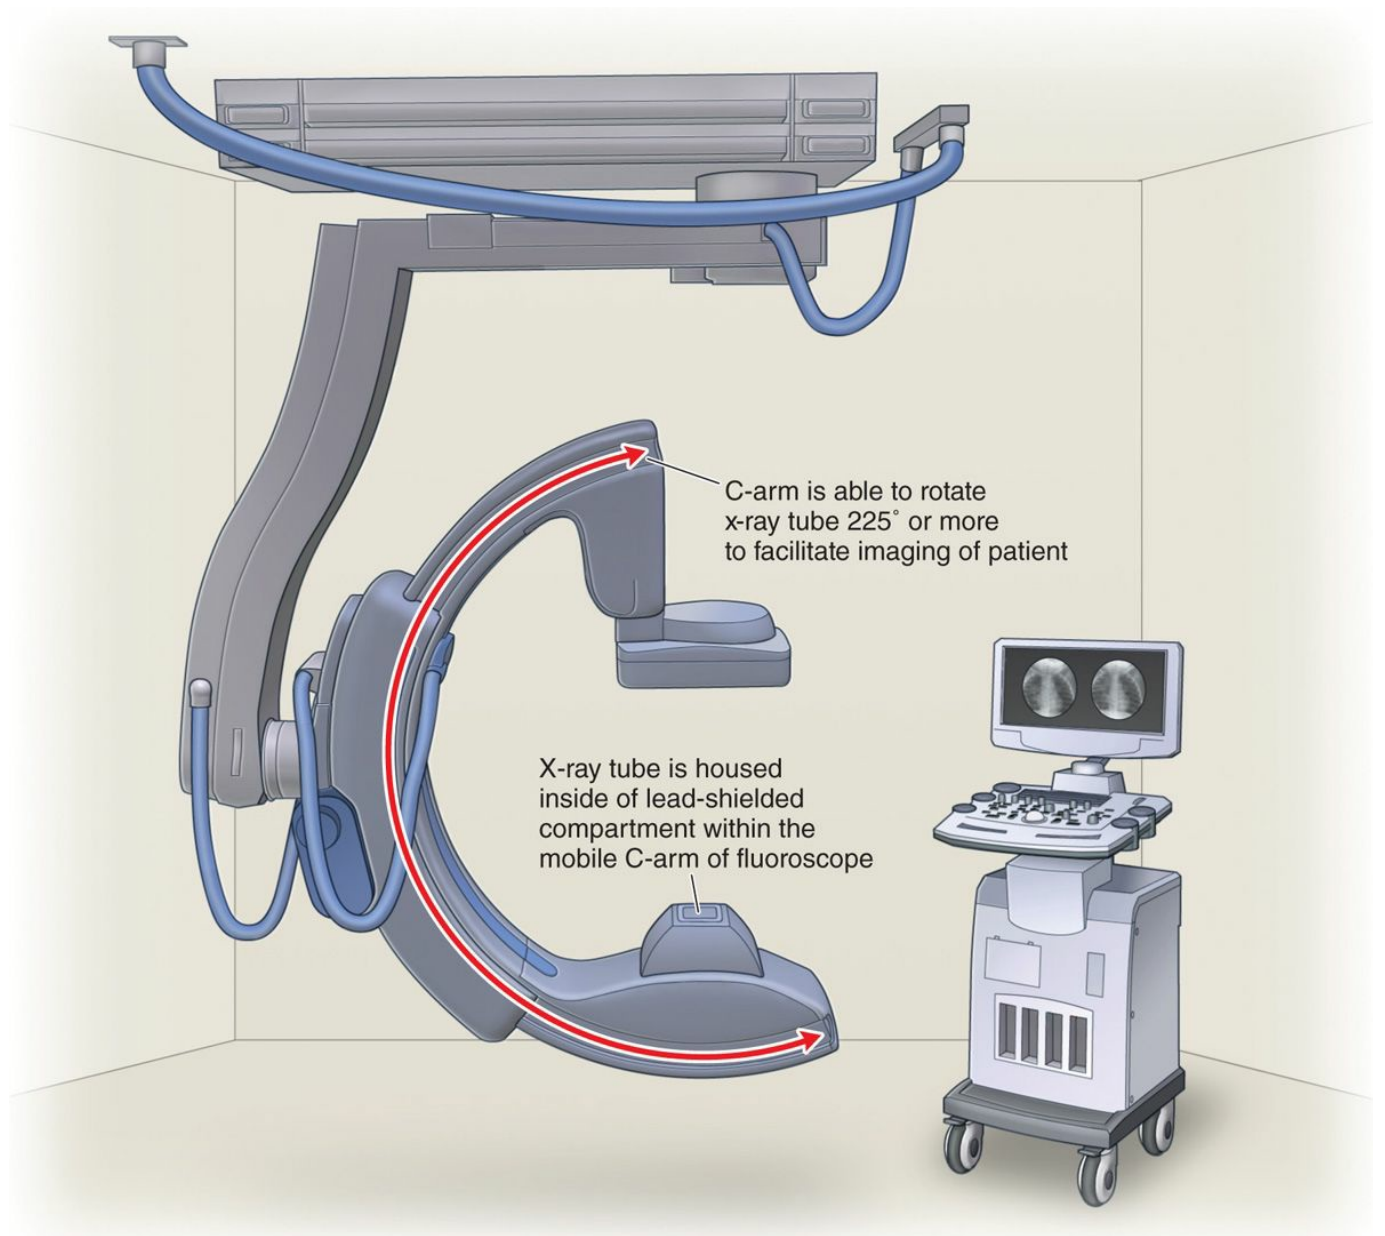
Modern fluoroscope with a shielded x-ray tube contained within a movable C-arm.
